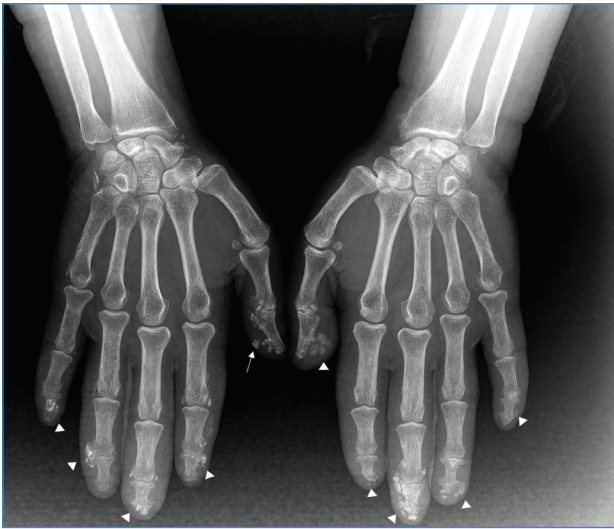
Hand radiographs showing calcinosis in all fingers
